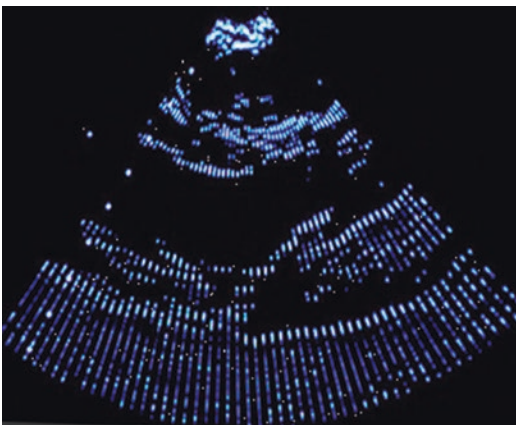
(Left) Ultrasound image made in 1977 prior to introduction of scan converters and (Right) from a modern machine. The scan converter interpolates the spaces
